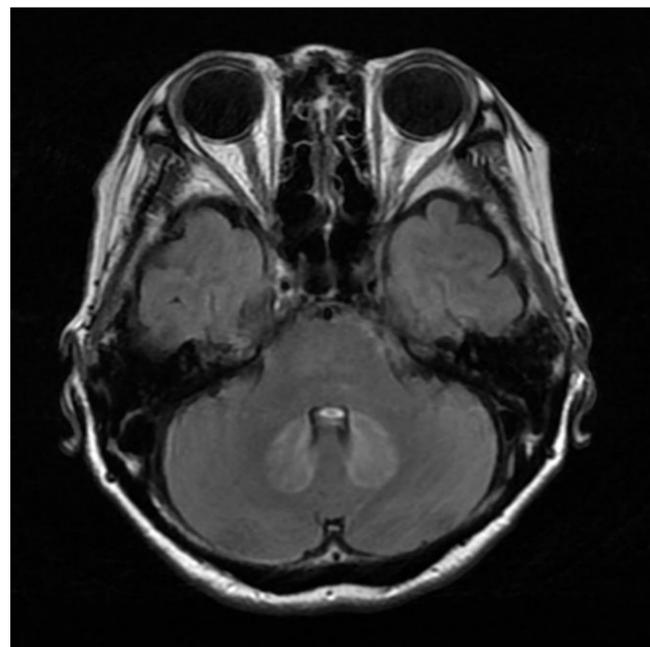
Brain MRI : T2 Weighted Image
